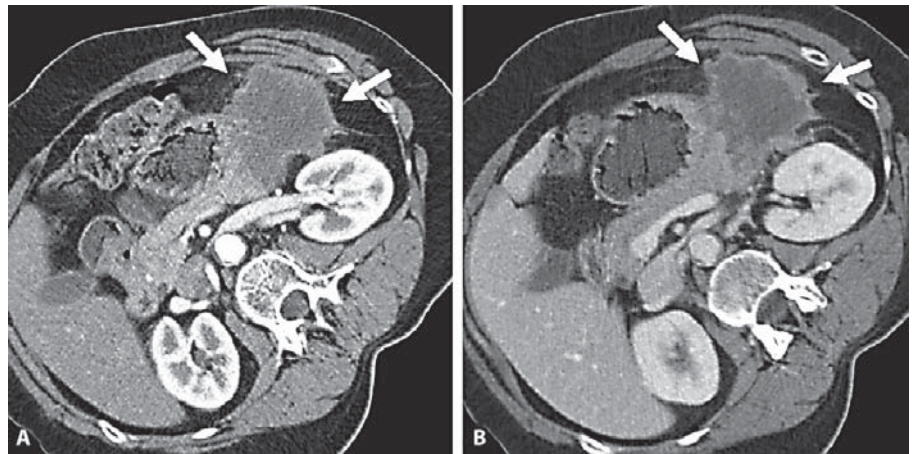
Arterial (A) and venous (B) phase CT images of a colorectal metastasis. The outer rim of the colorectal metastasis has the same enhancement as normal pancreatic tissue, while the inner area has no enhancement at all, due to a large central necrosis.
